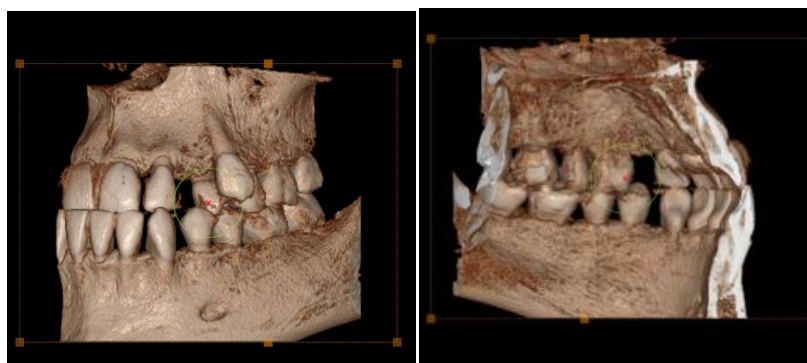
Radiographic investigations corroborating MxCP1 transposition diagnosis
